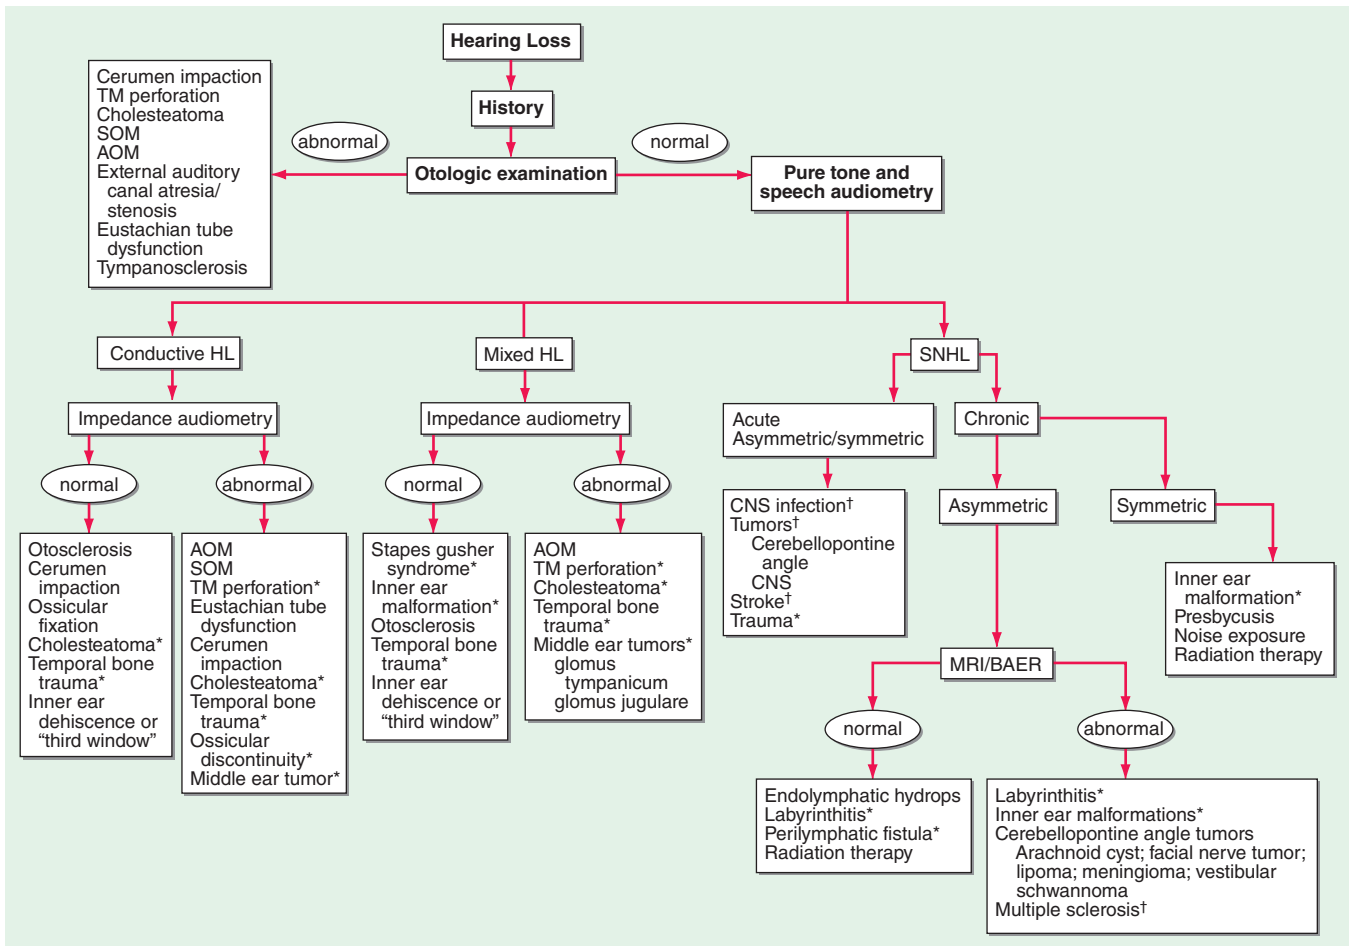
An algorithm for the approach to hearing loss. AOM, acute otitis media; BAER, brainstem auditory evoked response; CNS, central nervous system; HL, hearing loss; SNHL, sensorineural hearing loss; SOM, serous otitis media; TM, tympanic membrane. *Computed tomography scan of temporal bone. †Magnetic resonance imaging (MRI) scan.
